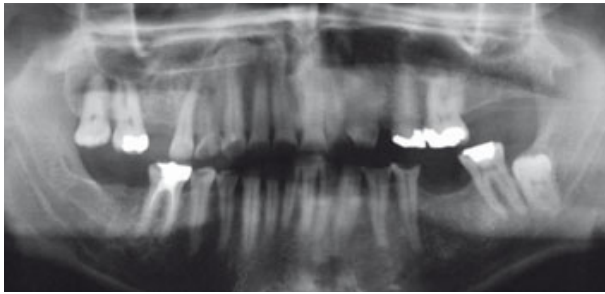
Pre-op panoramic radiograph.
